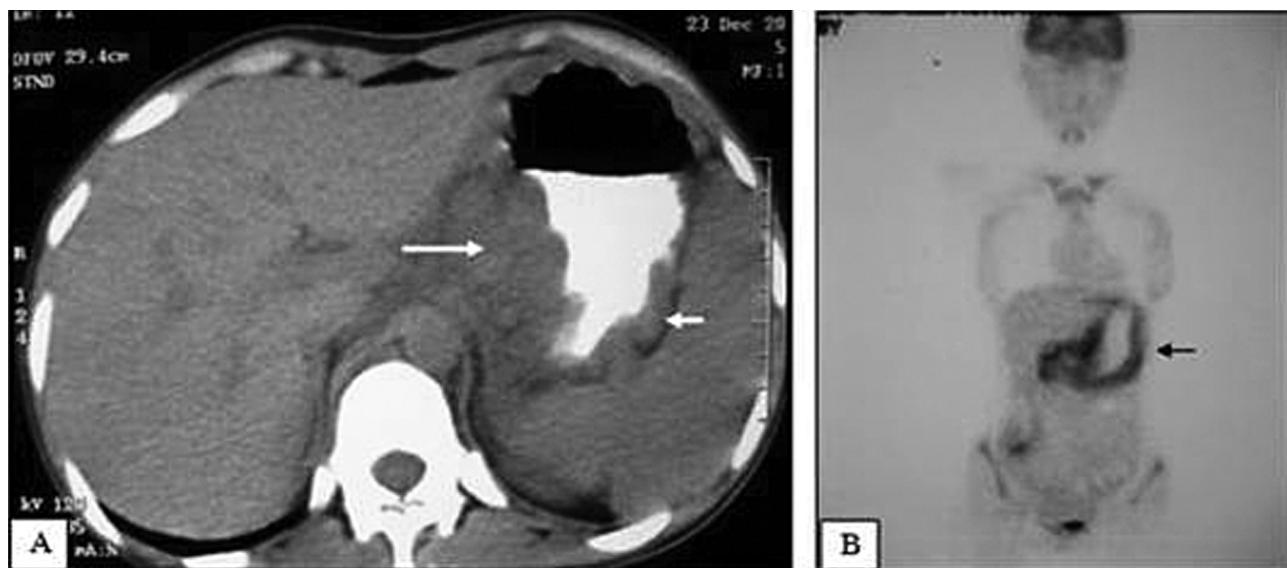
Computed axial tomographic scan image revealed a thickened gastric wall (arrow) (A). Coronal PET CT image demonstrated inflammation of the gastric wall (B).
